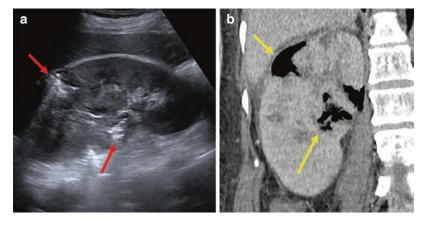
Emphysematous pyelonephritis is a necrotizing form of infection producing gas, which appears as illdefined echogenicities on ultrasound (a, red arrows) with posterior shadowing. Coronal CT demonstrates gas within
